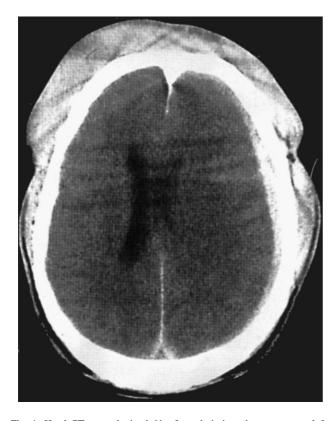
Head CT scan obtained 6 h after admission, demonstrates a leftsided acute subdural hematoma (1.8 cm in its largest diameter). Note also the effacement of the left lateral ventricle and the midline structure shift.
